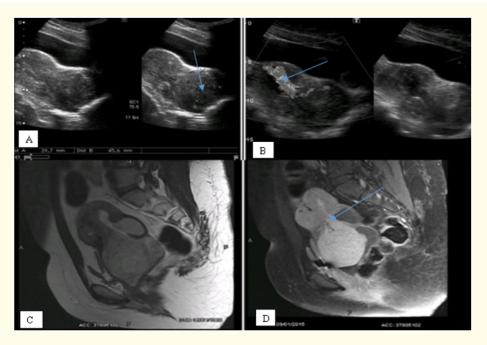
Case Two, Ultrasound (A, B) shows a well-defined lobulated lesion in upper vagina showing vascular pedicle (arrows). MRI (C, D) shows a well-defined, lobulated abnormal signal intensity mass lesion with significant vascularity and surrounding hemorrhagic fluid distending the cervical canal and upper part of the vagina. It has a well-defined stalk arising from anterior myometrium (arrow).
